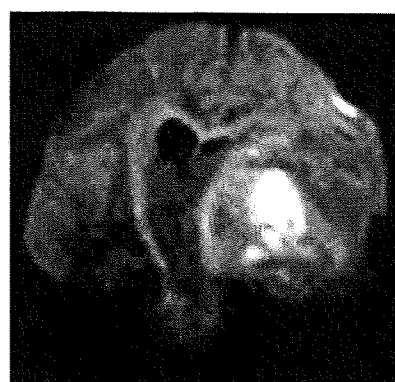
Intraoperative DWI obtained on MRI scanner with a magnetic field strength of 0.3 Tesla: both pyramidal tracts are clearly seen and the shift on the affected side can be easily evaluated.
